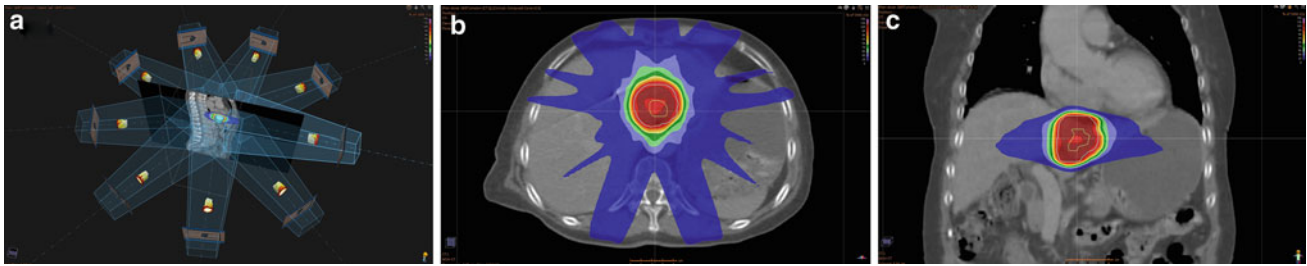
Representative SBRT plan for an intrahepatic tumor. A total of 50 Gy was delivered over 5 separate 10 Gy fractions. a Radiation planning representation of a nine-beam SBRT plan. b Axial CT slice through the isocenter showing the GTV (yellow unfilled central
